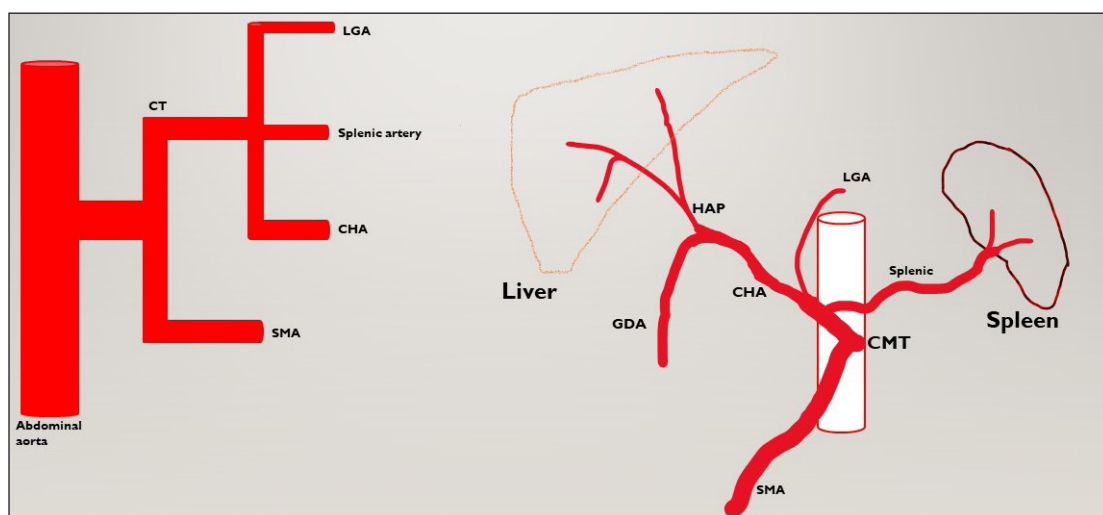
Depicting the common origin of coeliacomesenteric trunk. CT: Coeliac trunk, LGA: Left gastric artery, CHA: Common hepatic artery, SMA: Superior mesenteric artery, GDA: Gastroduodenal artery, HAP: Hepatic artery proper, CMT: celiacomesenteric trunk
